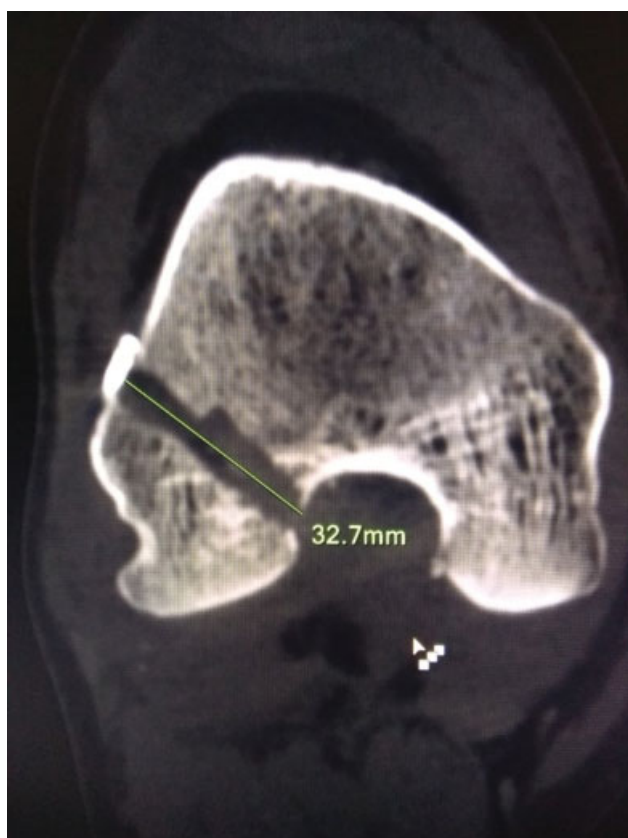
Axial curved reformatted computed tomography image visualizing the entire femoral tunnel and measuring the exact femoral tunnel length.
